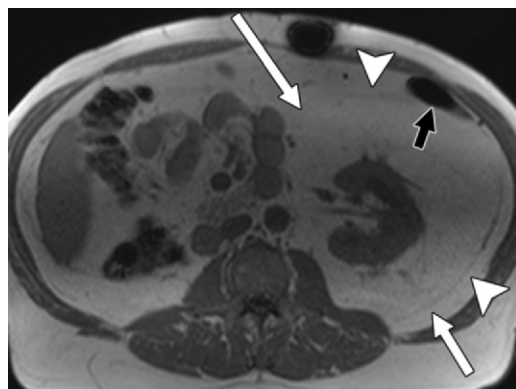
Retroperitoneal lipomatosis in a 57-year-old man. Axial T1-weighted MR image shows marked accumulation of fat in the left perinephric space (white arrows), with distension of the renal fascia (arrowheads) and anterior displacement of the descending colon (black arrow). The patient underwent a right nephrectomy for RCC and was found to have perinephric lipomatosis.
